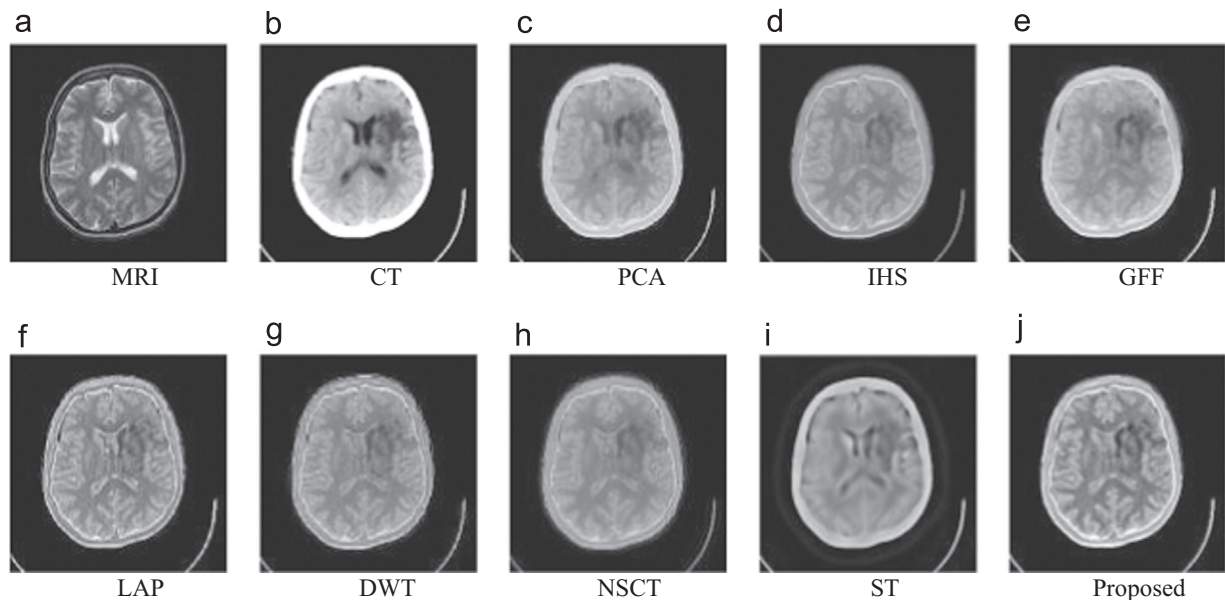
Example 2: Performance comparison of different methods on MRI-CT fusion.
